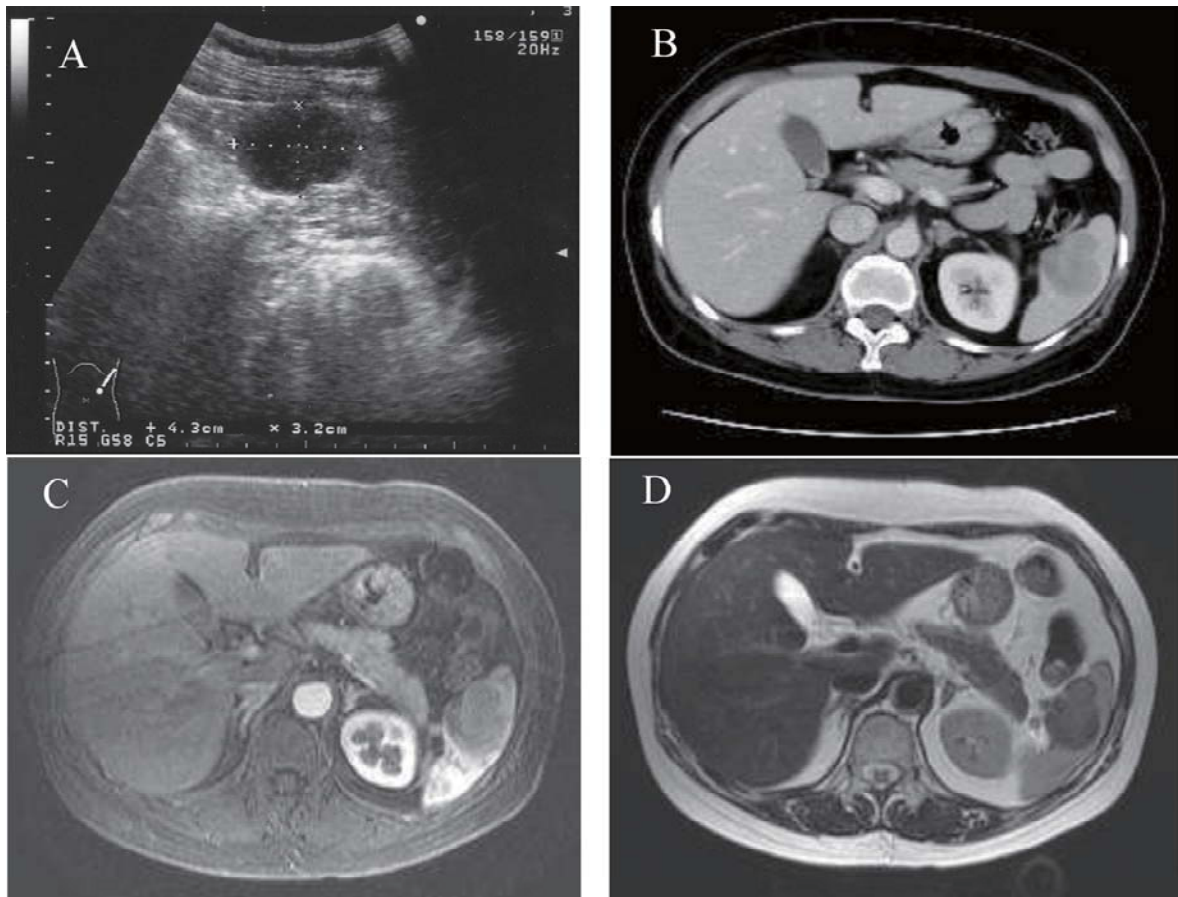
Preoperative findings by imaging modalities. A, US shows hypoechoic 4.3 × 3.2 cm mass in spleen; B, Enhanced CT scan showed intrasplenic homogeneous low-density 3.5-cm mass in the spleen; C and D, Both T1 and T2-weighted MRI shows heterogeneous low-signal intensity mass in spleen.
